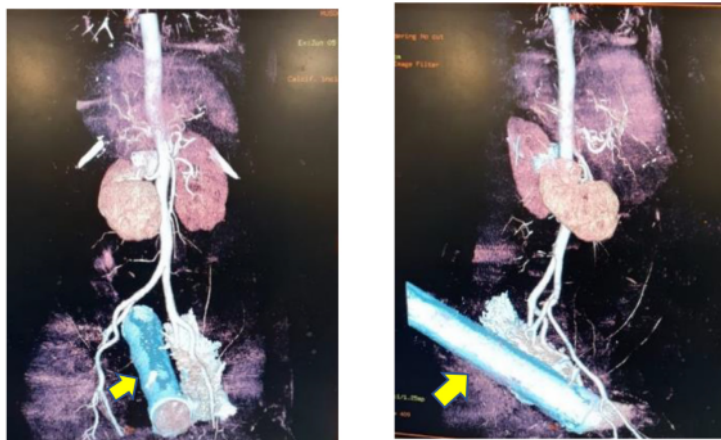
Abdominal 3D CT-scan shows the structure that is passed by the iron (arrow).
